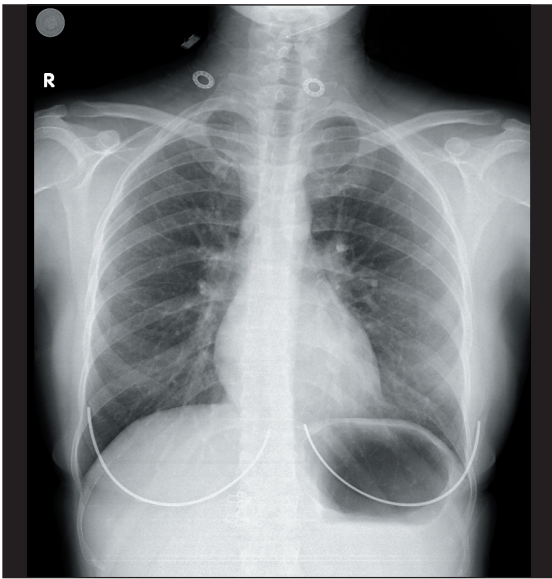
Follow-up postero-anterior chest radiograph obtained on day 15 after benralizumab, demonstrating near-complete clearing of the previous peripheral opacities.
